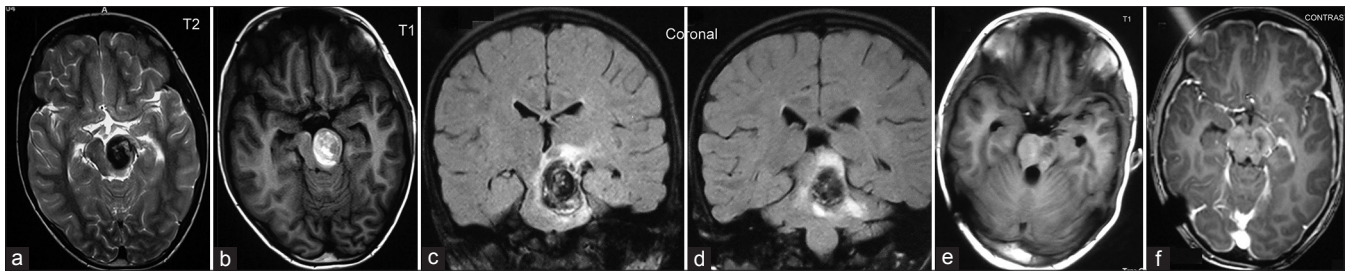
Axial MRI showing lesion heterogeneously hypointense on T2 (a) and hyperintense on T1 (b), occupying almost the entire left half of midbrain, suggestive of bleed. (c and d) show coronal MRI revealing the vertical extent of the vascular lesion (cavernoma) from the upper midbrain to the upper pons. (e and f) CEMRI after 8 weeks of surgery showing complete removal of the lesion
